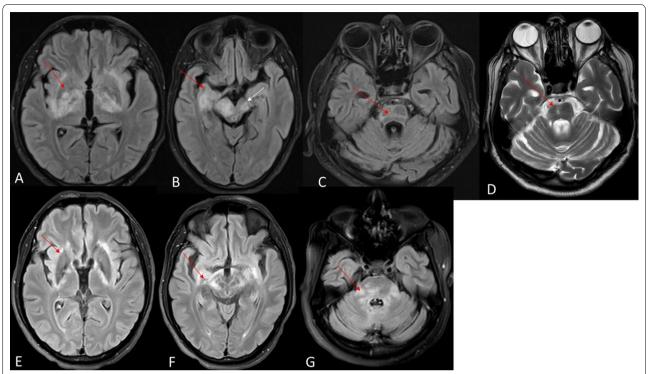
MRI brain of patient 6 (A, B, E, F). A, B axial FLAIR images show hyperintense lesion in bilateral basal ganglia, right medial temporal lobe and midbrain (red and white arrows); E, F axial FLAIR images showing decrease in lesion with treatment; C, D axial FLAIR and *T*2 images of patient 8 showing pontine hyperintense lesion with ponto-cerebellar atrophy (red arrows); axial FLAIR images of patient 9 showing pontine, bilateral middle cerebellar peduncles and cerebellar lesion (red arrows)
